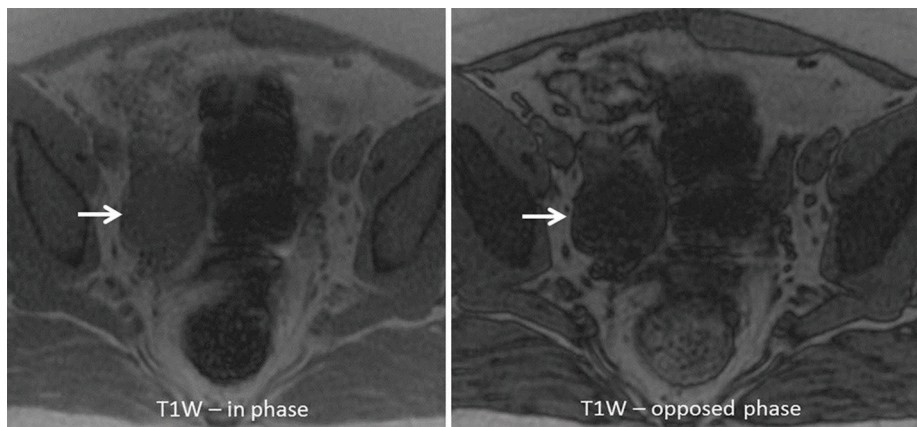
Axial pre-contrast T₁WI MRI of the pelvis demonstrating the same mass (arrows) seen on Fig. 1. It showed drop of signal on T₁W opposed phase (right image) compared to T₁W in-phase imaging (left image), consistent with lipid content within the mass. T₁WI, T₁-weighted image.
